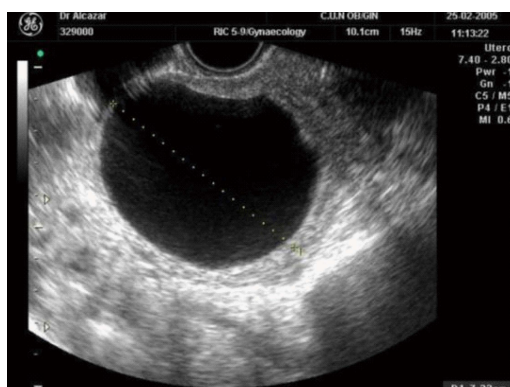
Transvaginal ultrasound showing an ovarian simple cyst as a round anechoic thin-walled cyst with no irregularity on the internal wall.
